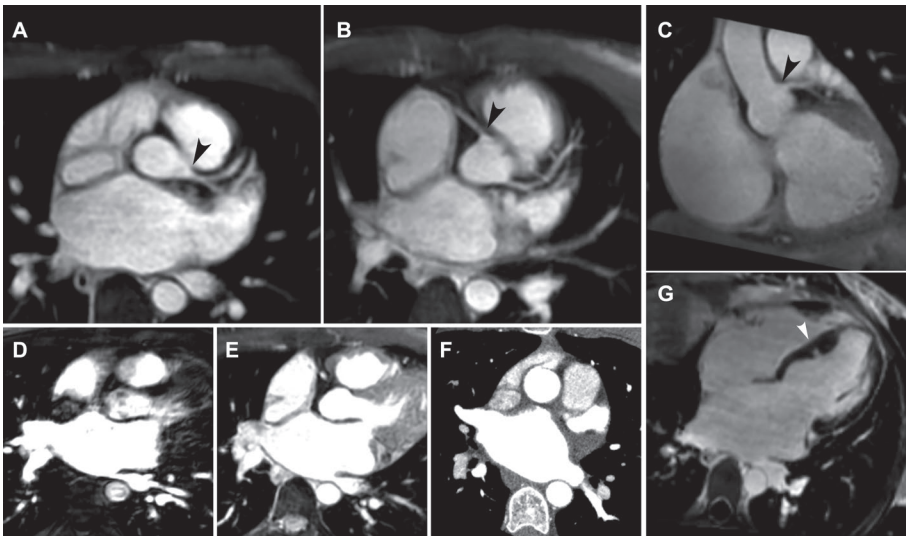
Example of a comprehensive cardiac MR examination prior to catheter ablation for atrial fibrillation: a 38-year-old woman, scheduled for reablation. (A–C) Reformatted transverse (A,B) and coronal (C) Dixon water-images for the identification of the left main (LM) coronary artery, which serves as an anatomic landmark for the integration of the MR images with the electro-anatomical maps. Note the origo of the left and right coronary arteries (black arrows). (D) Contrast-enhanced MRA of the pulmonary veins for the evaluation for anatomic variants. In this patient, the left upper and lower lobe pulmonary veins have one common ostium into the left atrium, while the right pulmonary veins drain into separate ostia. The presented image shows the left common ostium and the right upper ostium. (E) Noncontrast-enhanced Dixon water-image of the ostia of the pulmonary veins. (F) For comparison, the contrast-enhanced CT image of the ostia of the pulmonary veins is provided. (G) Reformatted 4-chamber late gadolinium enhancement (LGE) for the evaluation of myocardial scar. Note the midventricular septal hypertrophy with a deep myocardial crypt (white arrow).
